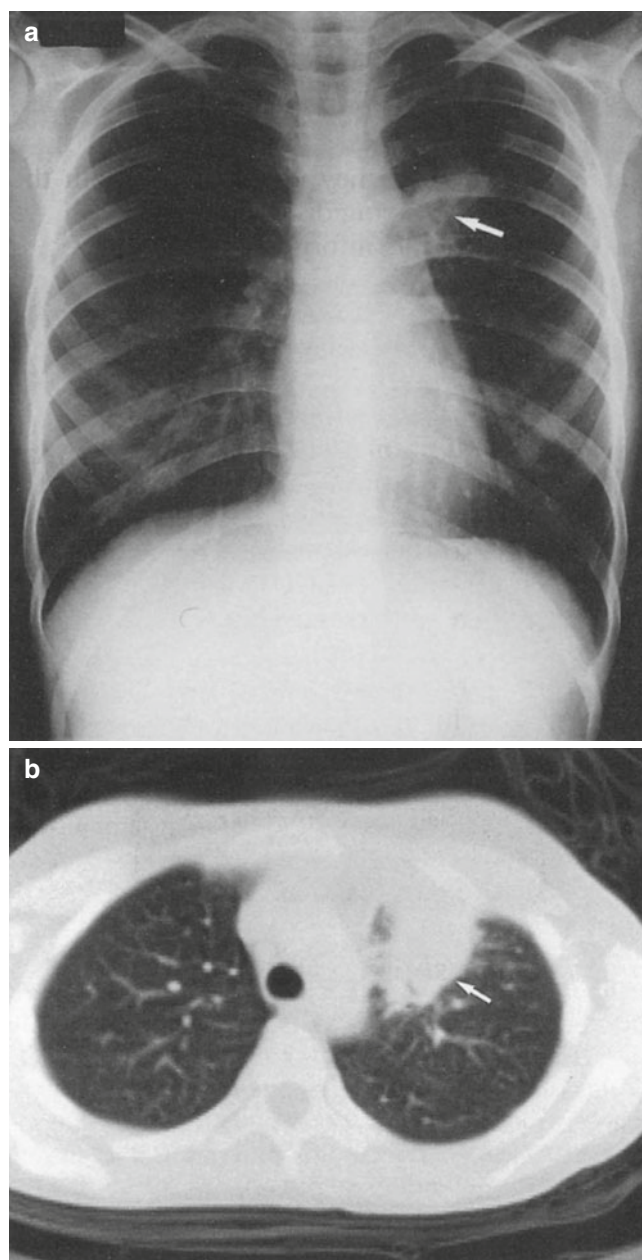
(a, b) Aspergilloma. This patient, undergoing bone marrow transplantation for a relapsed leukemia, developed an invasive aspergilloma on her left upper lobe bronchus that was gradually eroding into her pulmonary vessels and causing her hemoptysis. Following a lobectomy and removal of the lesion she has made an uneventful recovery. (a) Chest x-ray of the patient. (b) CT scan of the same patient
